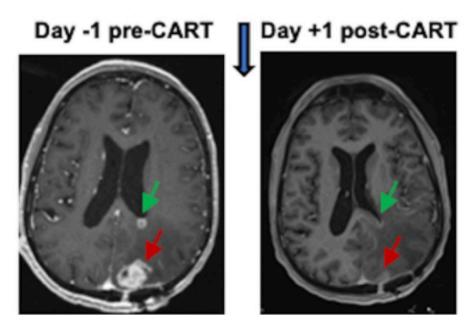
MRI scans of patients treated with CAR-T cell therapy. Images taken one day before CAR-T cell therapy and one day after CAR-T cell therapy. Red and green arrows indicate the tumor. There is evident tumor reduction (Source: Penn Medicine, 2024).
